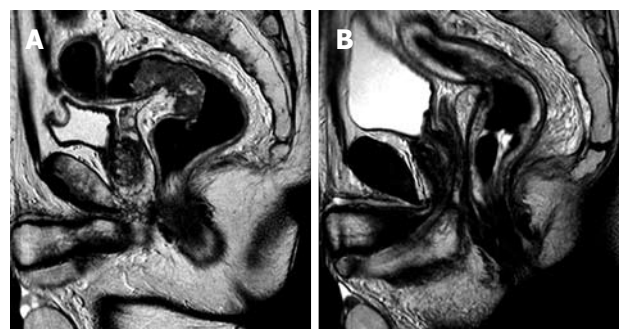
Rectal MRI. A: Before neoadjuvant chemoradiation treatment: evidence of perirectal fat tissue invasion, with fat spiculation, and enlarged mesorectal lymph nodes; B: After neoadjuvant chemoradiation treatment: reduction of tumor size, perirectal fat invasion, enlarged lymph nodes; non-homogeneous mesorectal fat tissue.
